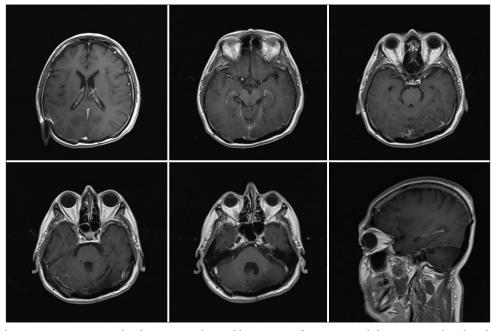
Six-month postoperative T1-weighted contrast-enhanced brain MRI of Case 1. Local disease control with radical resection of the tumor is demonstrated.
